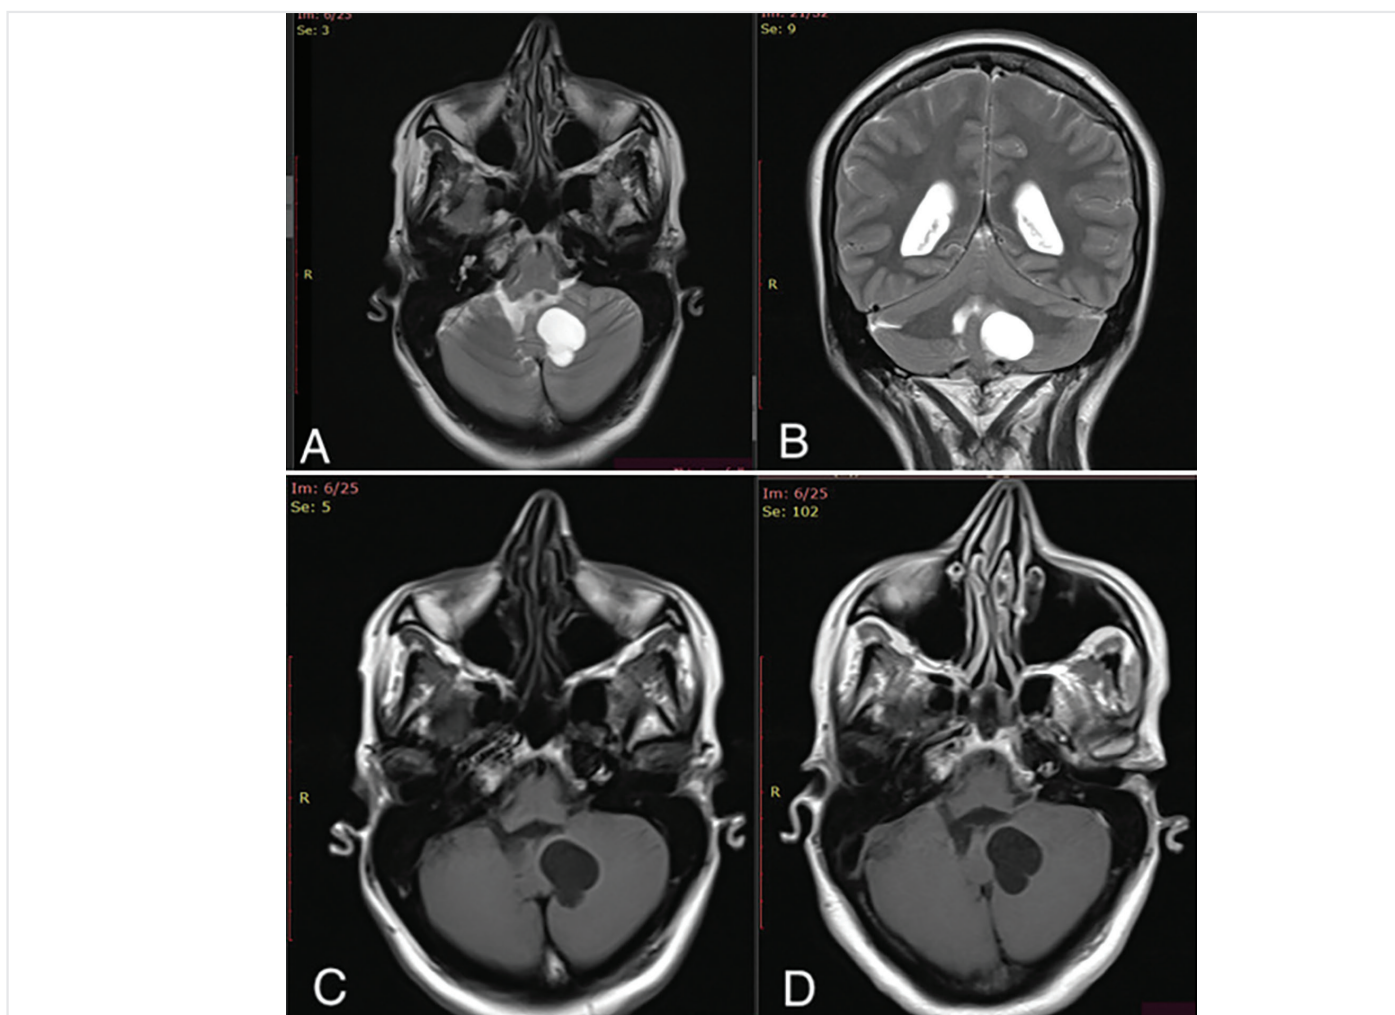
MRI revealing a well-defined cystic lesion in the left cerebellum. (A) Axial T2-weighted image and (B) coronal T2-weighted image demonstrate a hyperintense cystic measuring 24×21×20 mm. (C) Axial T1-weighted image shows the lesion as hypointense, and (D) axial contrast-enhanced T1-weighted image shows no enhancement of the cyst. The lesion causes compression of the fourth ventricle and brainstem
